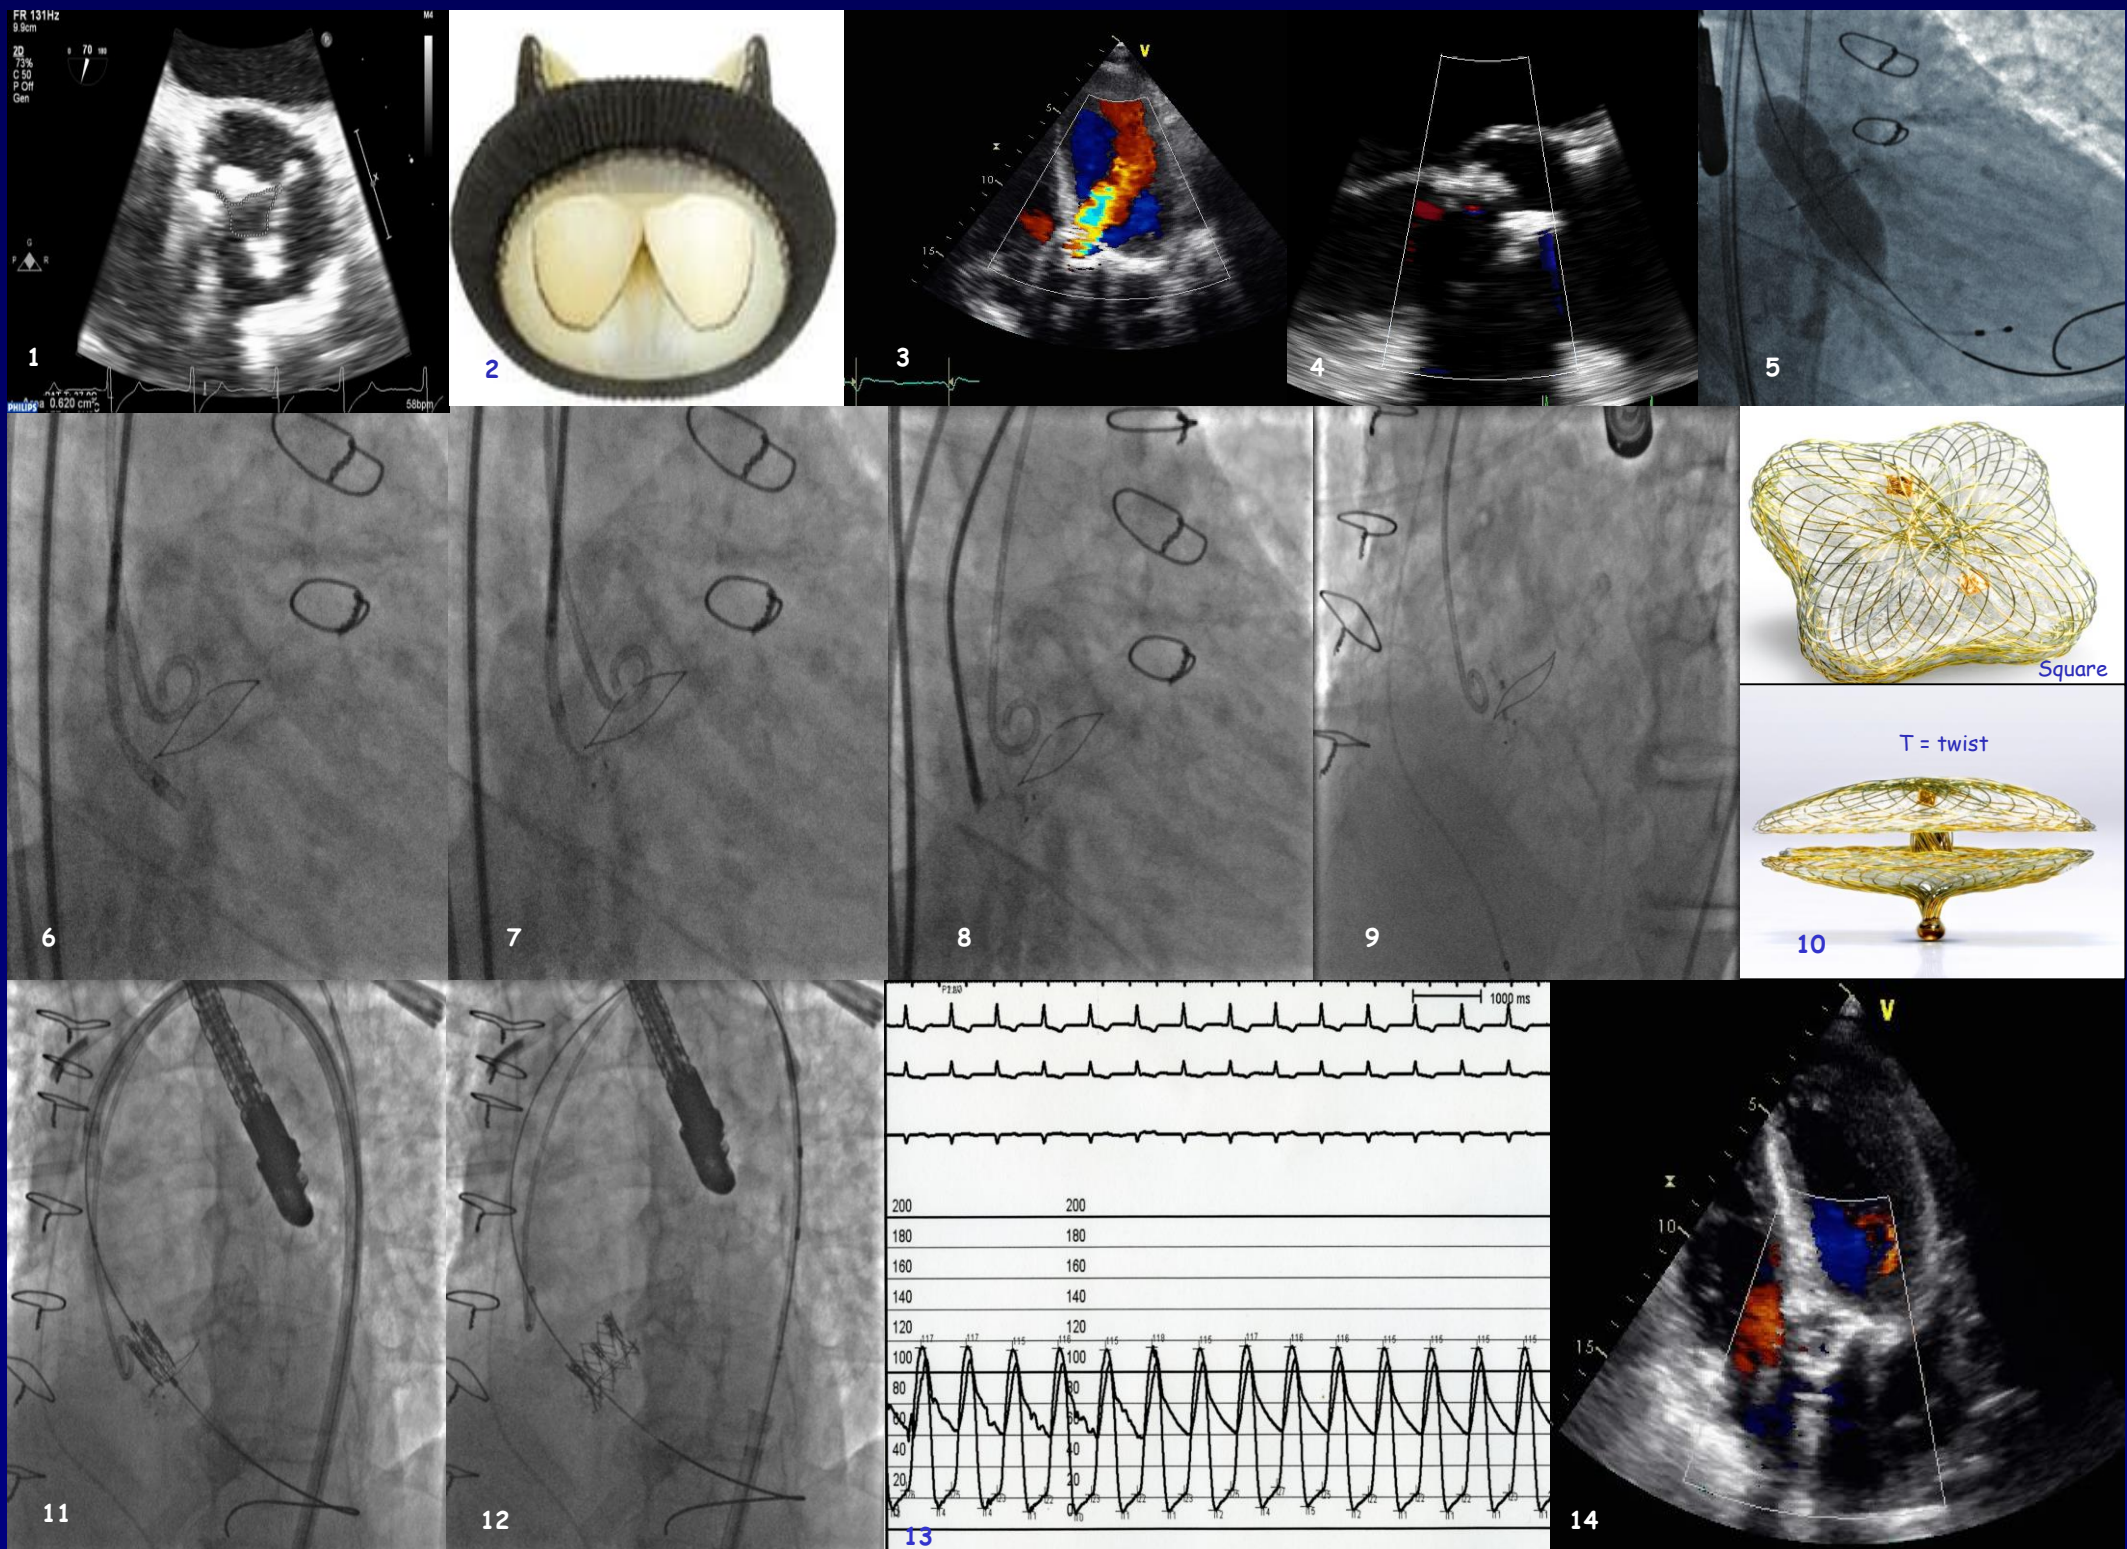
2D TEE (short axis) showing degenerated and severely calcified aortic bioprosthesis. Figure 2. Sorin Pericarbon More 23 bioprosthesis. Figure 3 and 4. 2D/3D TEE/TTE color Doppler (4-chambers and long-parasternal views) severe aortic regurgitation through paravalvular leak (largest diameter \approx 5 mm). Figure 5 Balloon aortic valvuloplasty (BAV) with a 20x40 mm NuMed (Z Med) balloon. Figure 6. 8F Judkins JR4 guiding catheter through the leak in the LV. Figure 7. Distal disc opening of the Occlutech® Paravalvular Leak Device (PLD) Square Twist 5 mm. Figure 8. Opening the proximal disc of PLD. Figure 9. PLD finally deployed. Figure 10. Occlutech® PLD Square Twist. Figure 11. Transcatheter Aortic Valve Replacement (TAVR) procedure with a Sapien XT 23 mm after BAV and PVL closure. Figure 12. Sapien XT 23 mm fully expanded. Figure 13. No significant transvalvular gradient, good diastolic pressure. Figure 14. 2D TTE color Doppler: no residual leak, no aortic regurgitation, LVEF \approx 40%.
